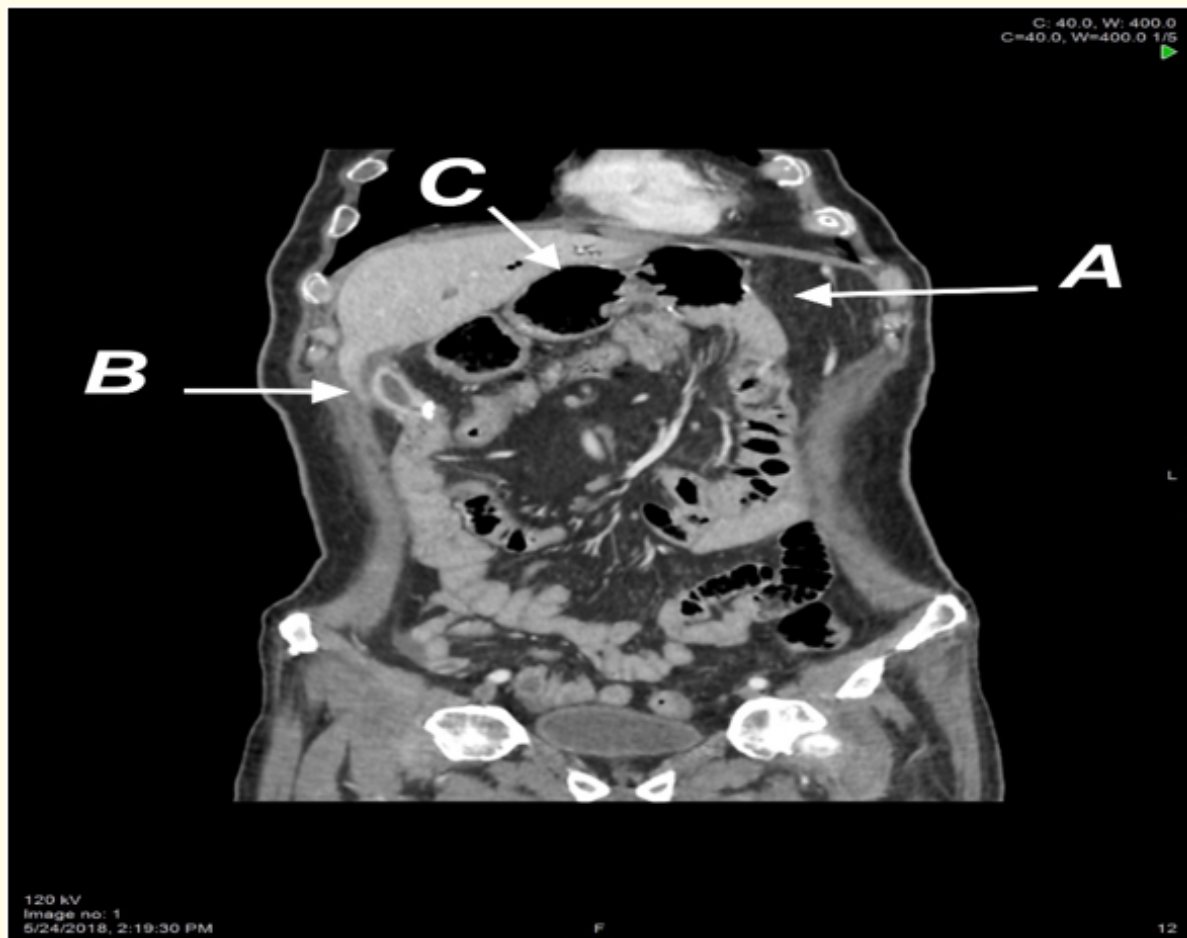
Routine CT abdomen and pelvis seven weeks post operatively. This Coronal view shows the proximal gastrojejunal anastomosis (A), the distal cholecysto-jejunal anastomosis (B) and the dilated first part of the duodenum (C).
